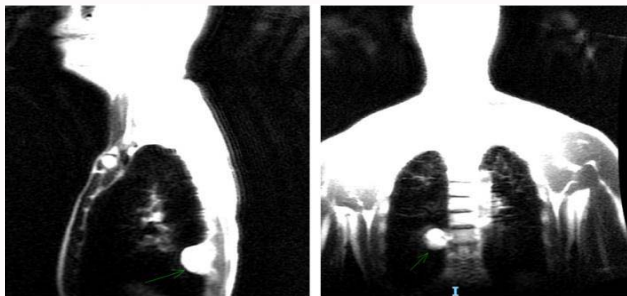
MRI showing redemonstration of pleural-based mass measuring up to 3.4 cm in largest dimension without mass extension into the neural foramina.
